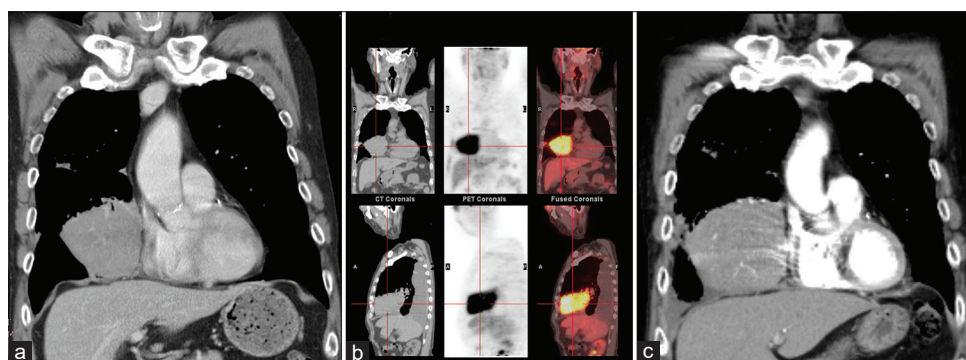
(a) Chest computed tomography revealing right middle lobe mass in December 2015 (b) Positron emission tomography-computed tomography showed localized tumor in the right middle lobe and no abnormal uptake in other regions of the body in December 2015. (c) Enlarged tumor complicated with right lower lung collapse and pleural effusion in June 2016
